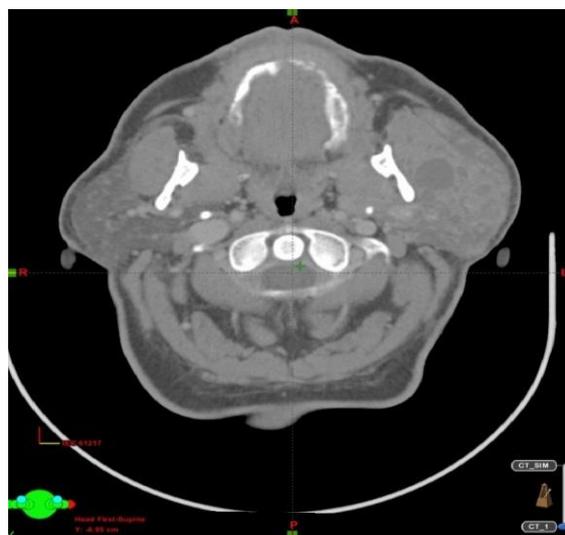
CT scan for a left parotid tumor
